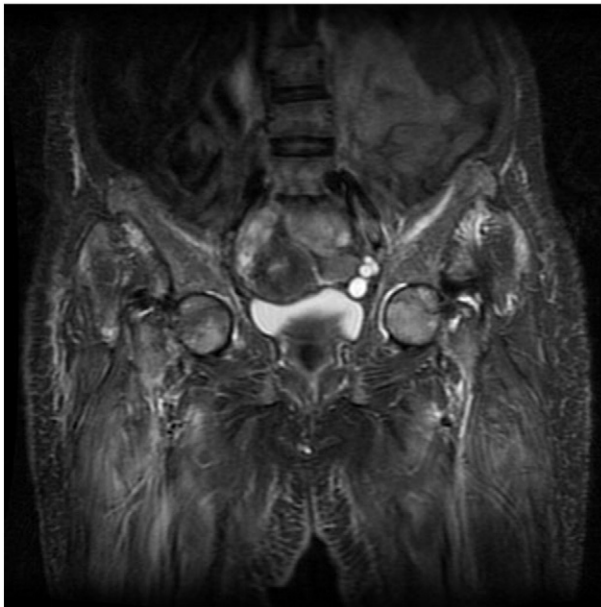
Magnetic resonance image showing necrotic area in both femoral heads.
